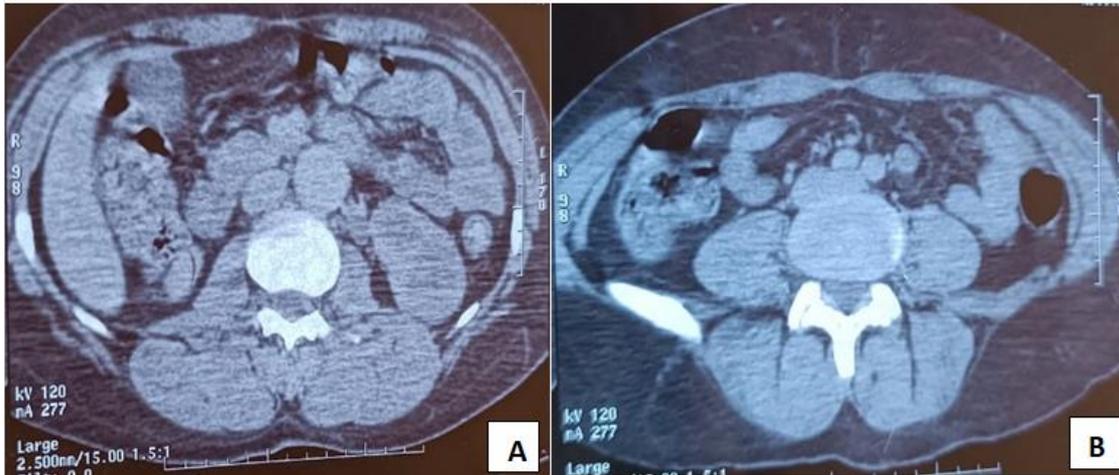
(A and B): Abdominal CT scan with contrast injection showing an enlarged pancreas with loss of lobulation of its contours, associated with infiltration of the peripancreatic fat
